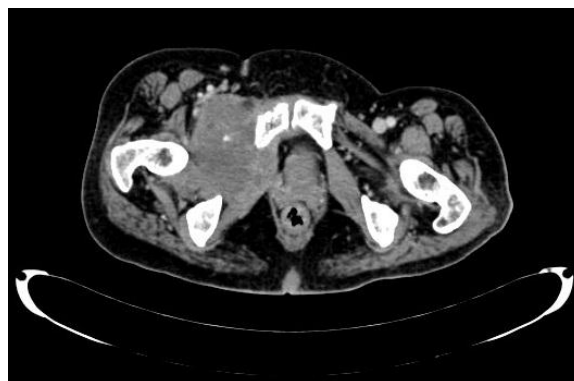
CT showing the lesion eroding the pubic ramus.
